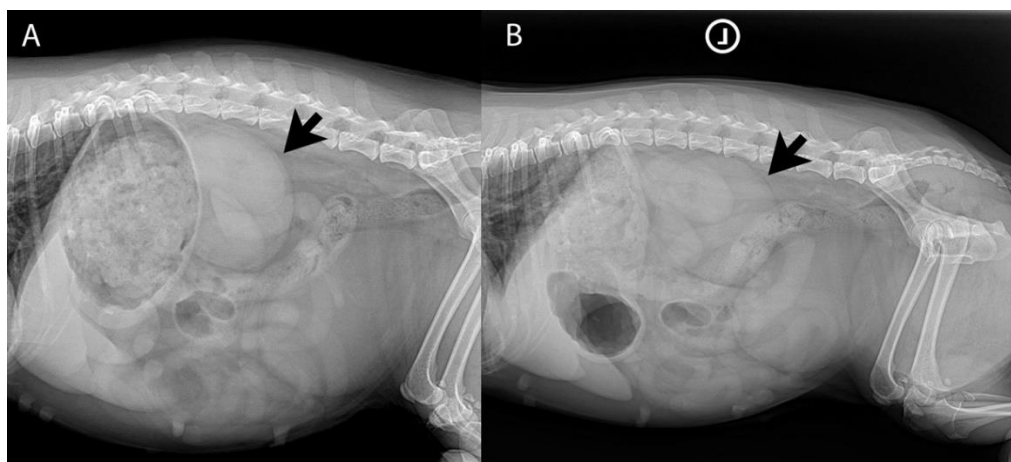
Lateral radiographs of the abdomen A – B Right and left lateral of the abdomen showing a soft tissue opacity structure (black arrows) beyond the stomach and causing displacement of the small bowels and descending colon.
